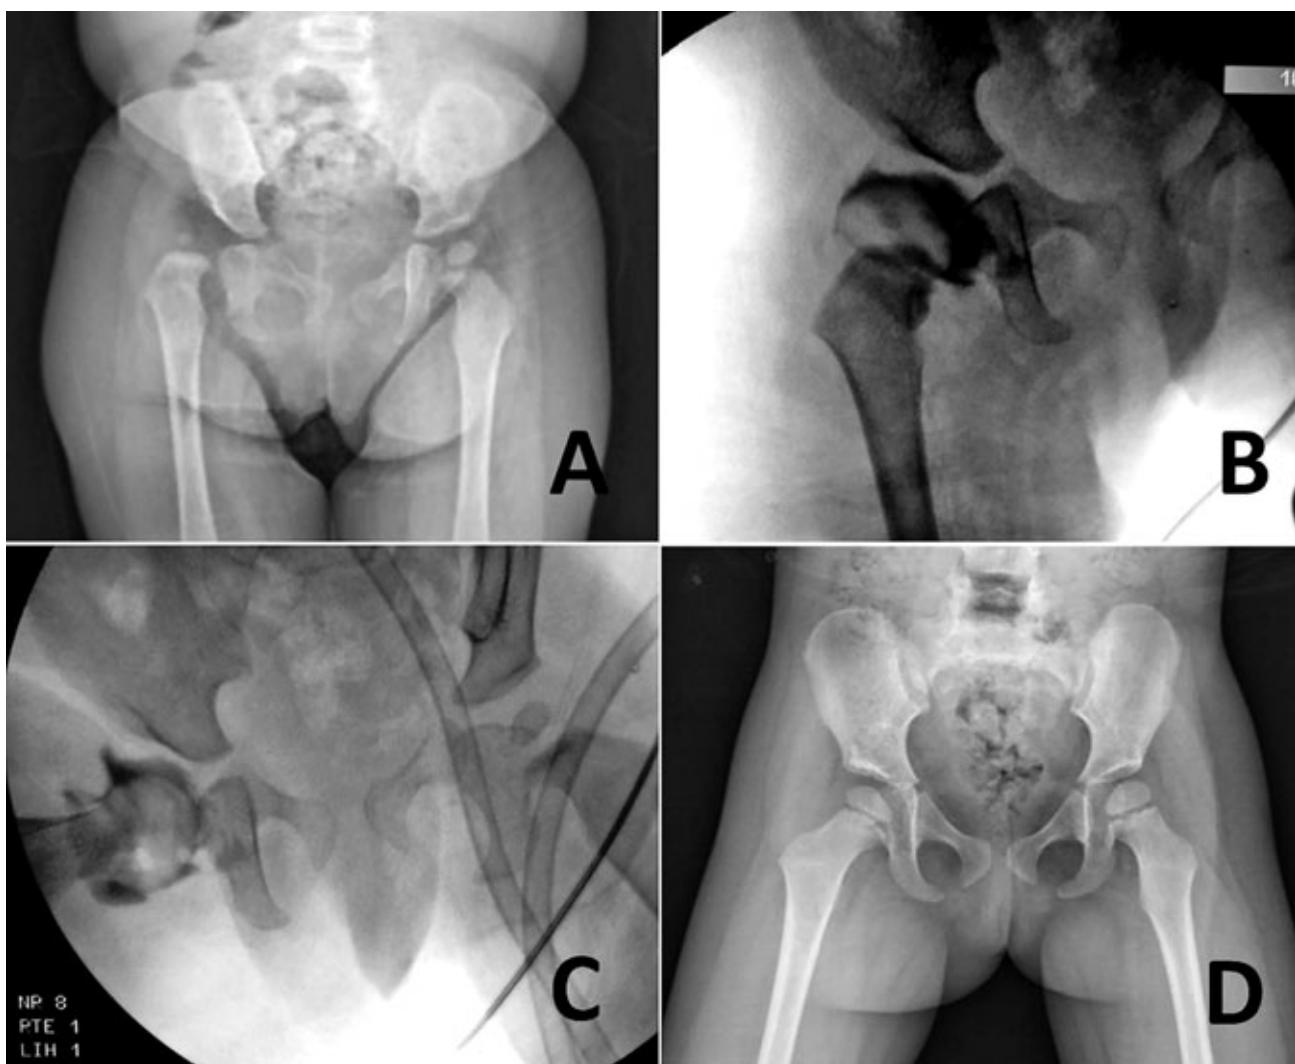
15-month-old patient's (A) pre-operative X-ray, (B) intra-operatif arthrography, (C) arthrography after adductor longus and iliopsoas tenotomies and (D) postoperative 21st month X-ray.
